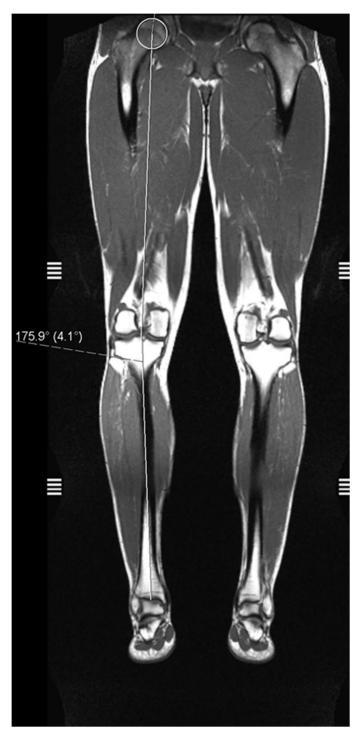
Static frontal plane knee joint alignment of both lower extremities obtained by image composition of coronal T1-weighted images centred to the ankle, knee and hip joint as described by Hinterwimmer et al. (25).
